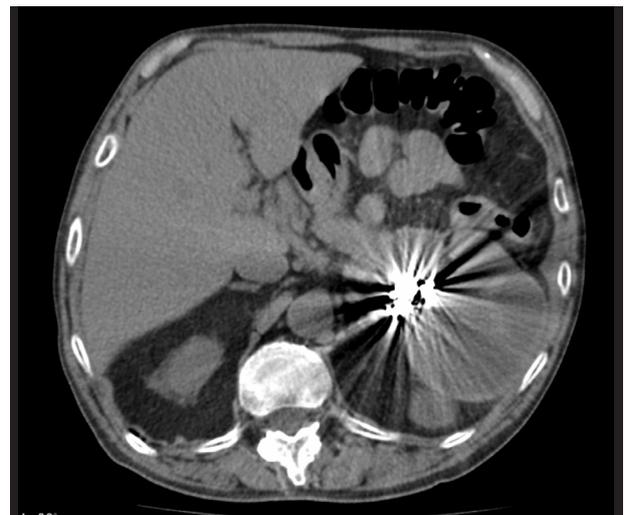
CTA 3 months after the procedure; CTA Computed Tomography Angiography
